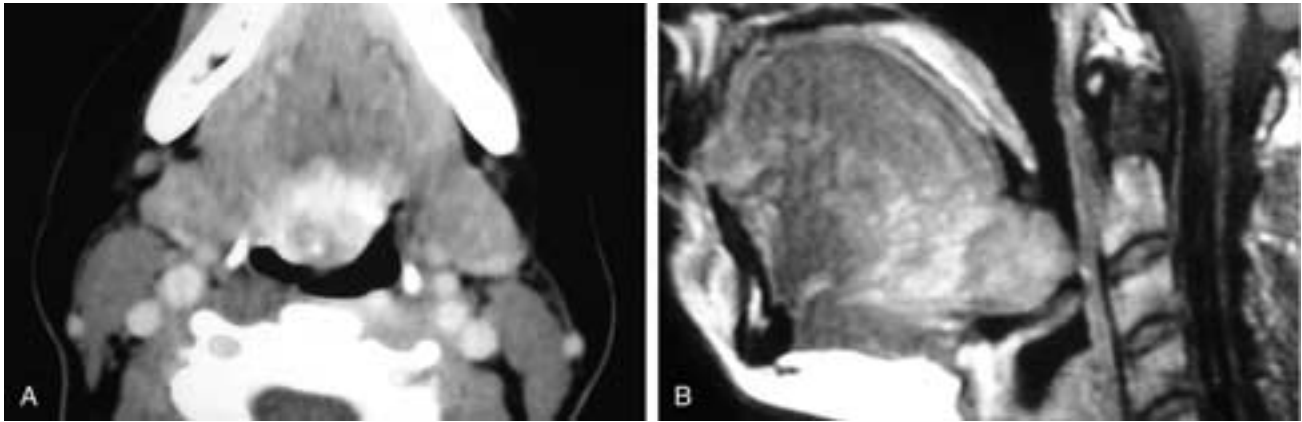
Axial contrast-enhanced CT scan (A) and a sagittal T1-weighted MR image (B) on a woman who developed dysphagia 1 week after delivering her first child. There is an enhancing mass in the midline base of the tongue. This was a goiter in a lingual thyroid, a fairly common occurrence in pregnant women. After surgery, pathologic examination revealed a focus of papillary thyroid carcinoma within the goiter.
